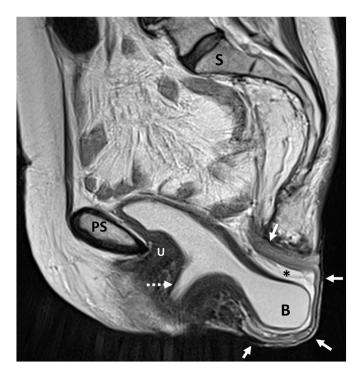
Single sagittal midline T2-weighted Fast Spin Echo (FSE) image with the patient at rest demonstrates complete anorectal prolapse (solid arrows) containing the bladder (B) and peritoneal fat (*). The bladder is also seen prolapsing though the vagina in the middle compartment (dashed arrow). PS - pubic symphysis; U - urethra; S - sacrum.
